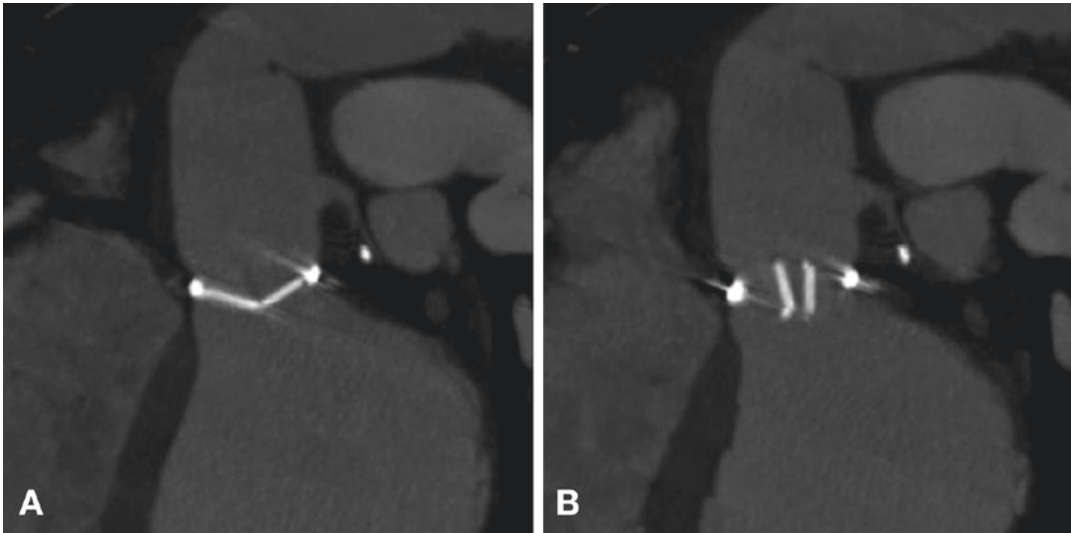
Two of ten reconstructions from a retrospectively gated CT through a mechanical aortic valve prosthesis demonstrate normal function with the valve closed in diastole (a) and open in systole (b)
